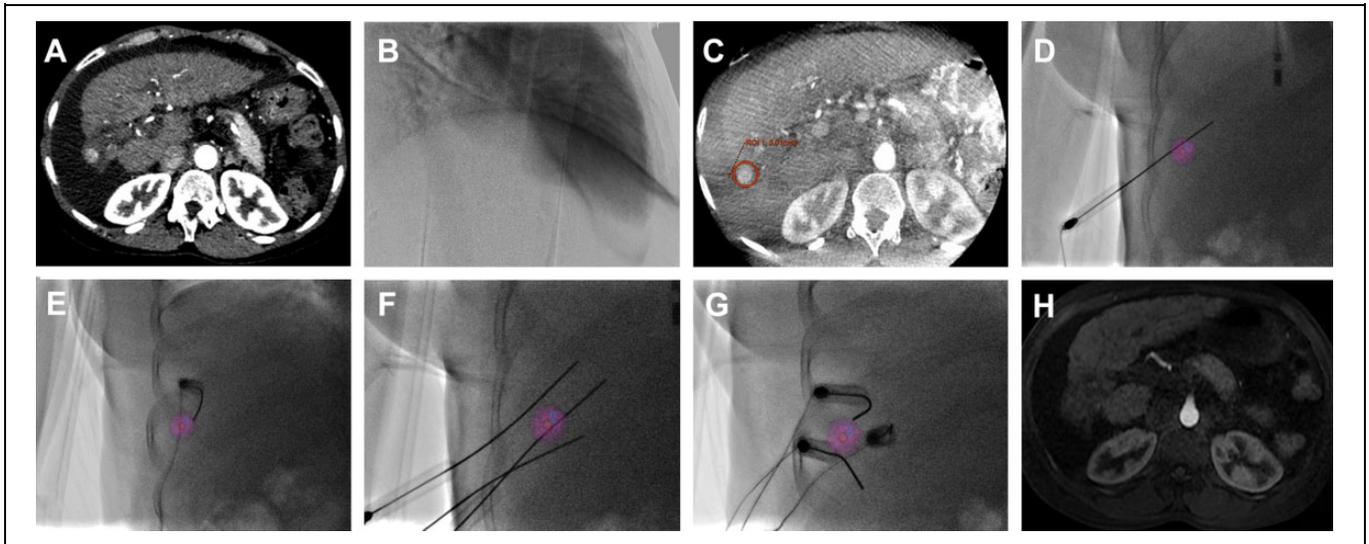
Irreversible electroporation ablation of a hypervascular tumor not visualized with US using 3D-VTFD from segmented CBCT acquired at the arterial phase of liver enhancement after the intravenous injection of iodinated contrast medium. A, Axial pretherapeutic CT of the liver acquired at the arterial phase after the intravenous injection of iodinated contrast medium revealing a small subcapsular hypervascular nodule in segment 6. Note the ascites linked to advanced cirrhosis which was the reason for choosing IRE for ablation. B, Cadenced subtracted lateral fluoroscopic images acquired following the intravenous injection of iodinated contrast medium which tracked the arrival of the bolus in the abdominal aorta (see also Supplemental Materials 2). C, On the 291 projections acquired at the liver arterial phase during 200° C-arm rotation at a speed of 20°/s (see also Supplemental Materials 2) the hyperattenuating tumor is segmented on CBCT images using a spherical tool. D to G, The target is then exported on a fluoroscopic image to provide the operator with a real-time 3D display as a function of the C-arm position. Fluoroscopic shots with different c-arm positions enable sequential guidance of the insertion of the 3 IRE probes and finally verify their geometrical arrangement. Continuous fluoroscopic acquisition can also be used to monitor needle progression or to check the geometrical arrangement of probe positioning (see Supplemental Materials 3). H, One month after the procedure, an axial MR T1-weighted image acquired at the arterial phase of an intravenous gadolinium contrast injection reveals a hypointense area encompassing the tumor boundaries and indicative of a complete response. 3D-VTFD indicates 3D virtual fluoroscopic target display; CBCT, cone beam CT; CT, computed tomography; IRE, irreversible electroporation; MR, magnetic resonance; US, ultrasound.
